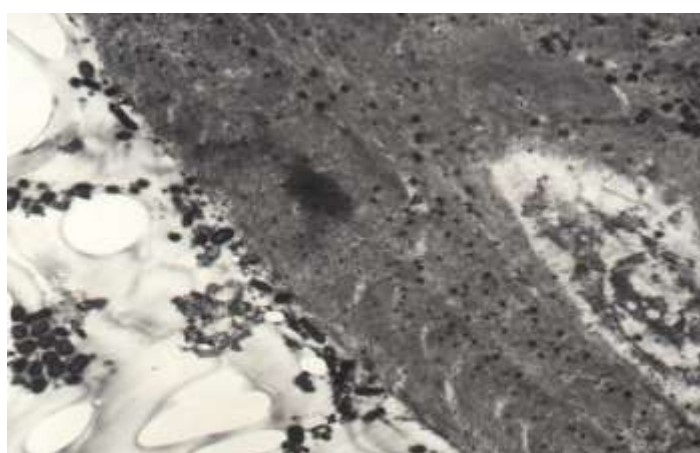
The decrease in the number of microorganisms and the preserved ultrastructure of bone tissue after the rehabilitation of the pathological focus with ultrasonic cavitation.
